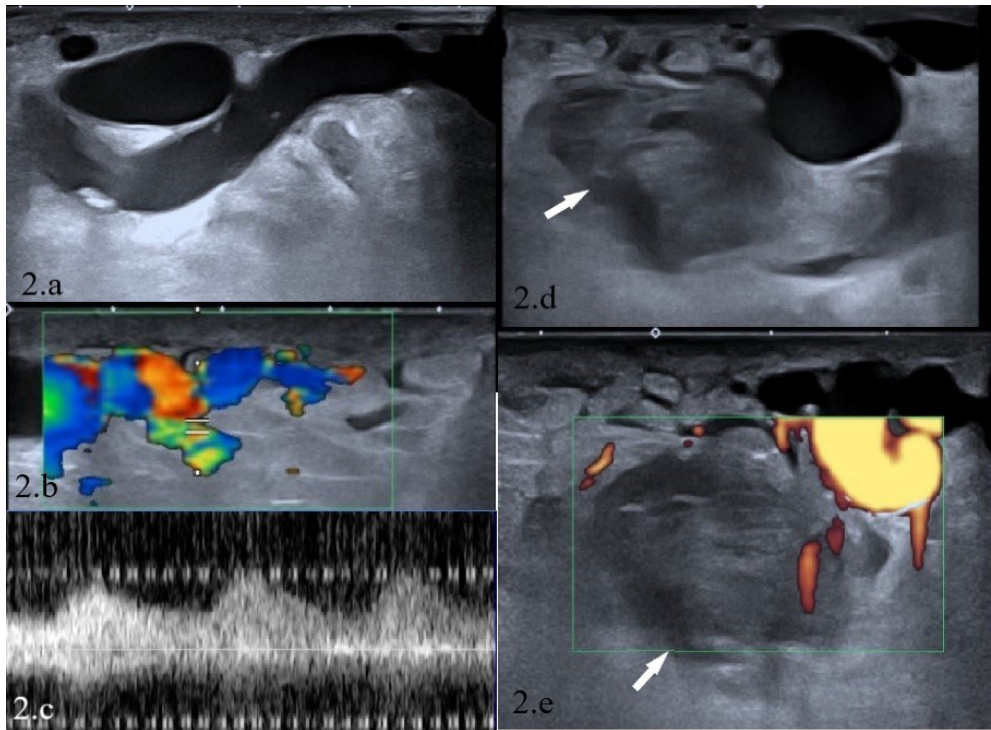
(a, b) Extensive dilated superficial vascular collaterals, cutaneous-subcutaneous fatty tissue edema, and echo increase; (c, d, e) hypo-isoechoic lesion (white arrow), Doppler examination indicating the presence of a low resistance arterial feeder, and arterialized high-flow velocity vein adjacent to the hypoechoic lesion with turbulent flow in its lumen, suggesting the presence of a partially thrombosed pseudoaneurysm-associated AVF.
